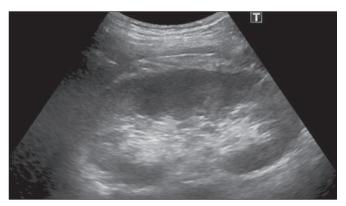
Ultrasound examination at 6 months of follow-up, showing complete regression of the representative cyst.
